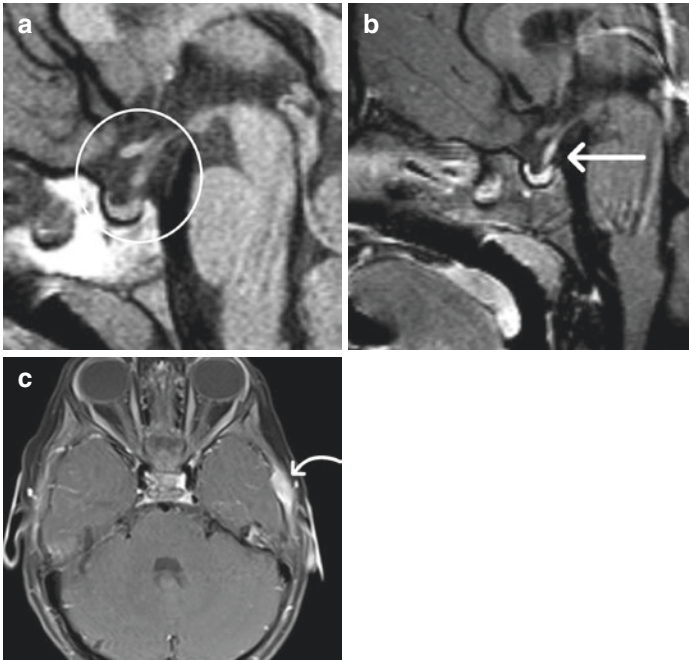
Langerhans' cell histiocytosis (LCH) MRI images of a 5-year-old boy with LCH. (a) Unenhanced T1 sagittal image showing absence of the normal posterior pituitary bright spot. (b) Postcontrast sagittal T1 with fat saturation demonstrate thickened enhancing pituitary stalk (straight arrow). (c) Postcontrast axial T1 with fat saturation shows enhancing left temporal bone lesion of LCH (curved arrow)
